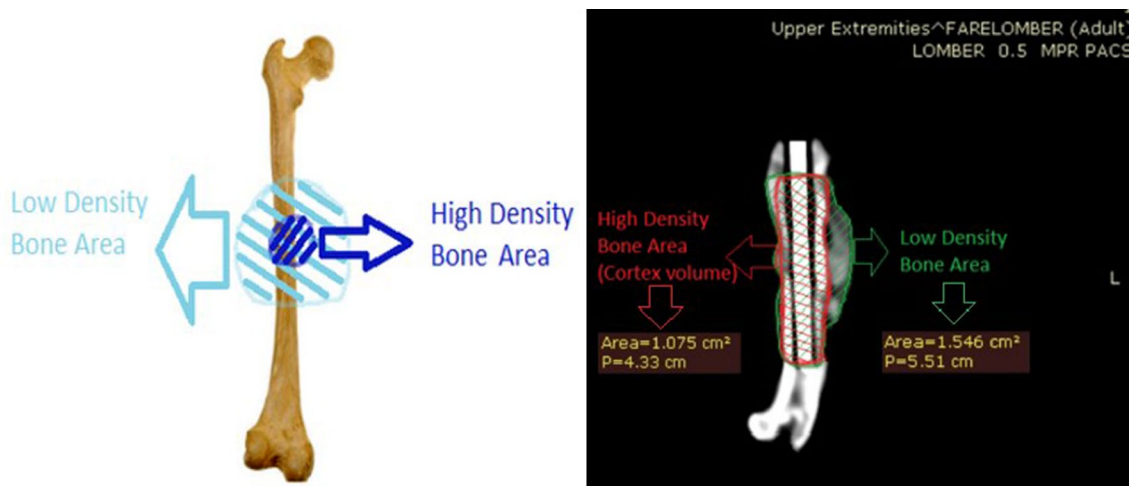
Measurement of micro-computed tomography longitudinal sections of newly formed callus tissue in the femur after sacrifice.
